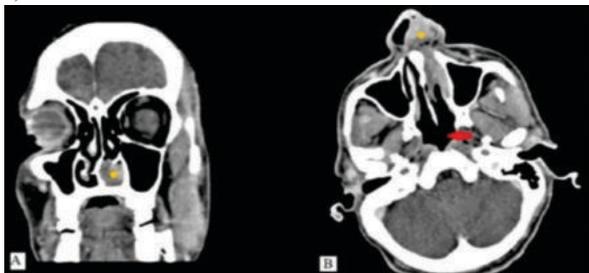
CT showing (A) soft tissue density in the left nasal cavity
